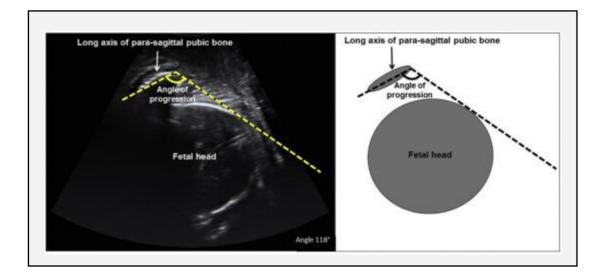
Transperineal ultrasonographic measurement of angle of progression.
